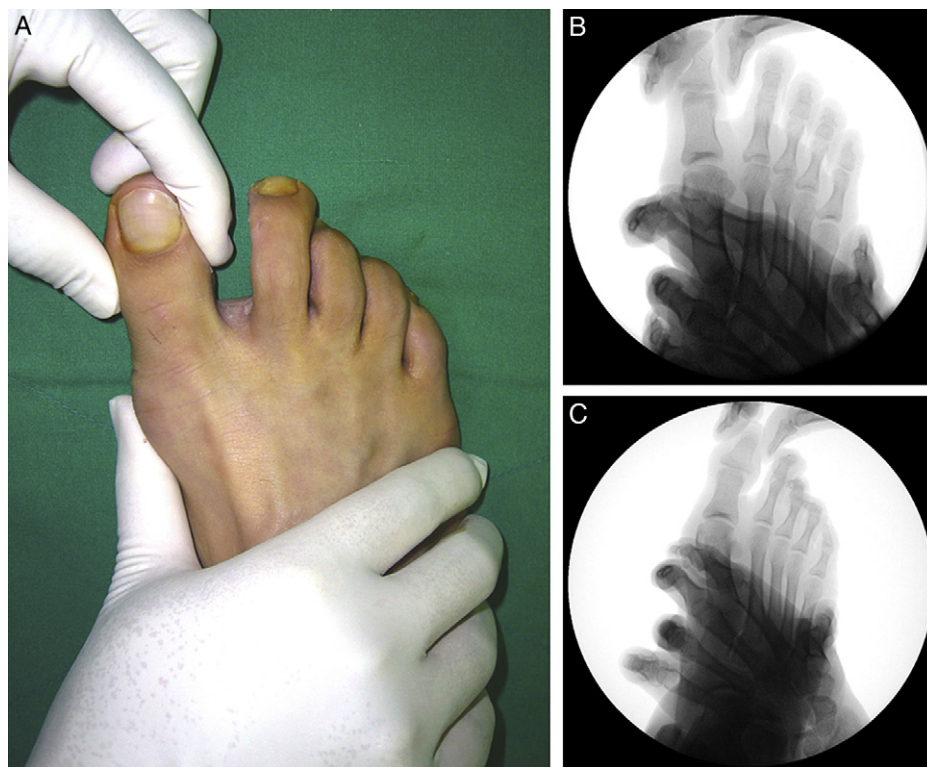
Lateral soft tissue contracture evaluated on the operating table. (A) Fluoroscopic foot anteroposterior radiograph taken with the forefoot held in 1 hand while squeezing at the metatarsal heads to reduce the first intermetatarsal angle, while the other hand pressed the lateral side of the great toe proximal phalanx to the medial side to apply varus stress. (B) When the great toe proximal phalanx could be forced back into straight alignment or with slight overcorrection to the long axis of the first metatarsal, distal chevron osteotomy with lateral soft tissue release was performed. (C) When it was not possible, proximal osteotomy was considered; these cases were excluded from the study.
